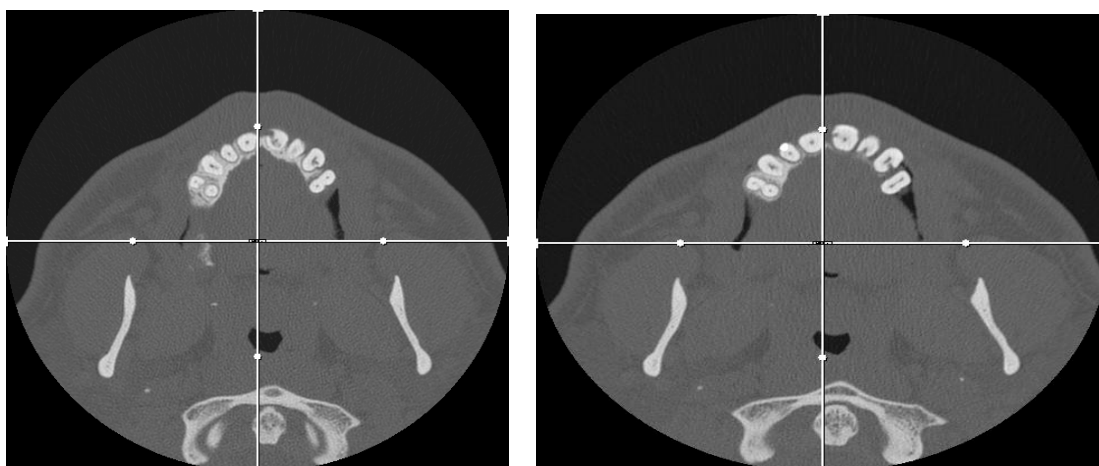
13 Axial CT-view showing defects of external and internal origin. Courtesy of dr. Mork-Knutsen
